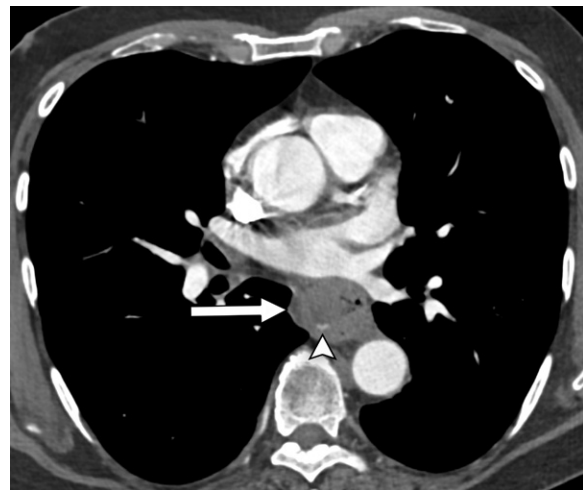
Esophagitis with possible active bleeding in a 62-year-old man with esophagitis, gastroesophageal reflux disease, and peptic ulcer disease who presented with chest pain and hematemesis. Axial arterial phase CT image shows diffuse esophageal wall thickening, fluid distending the esophagus, paraesophageal fluid (arrow), and a tiny focus of high attenuation in the posterior esophageal lumen that is concerning for active bleeding (arrowhead). However, contrast extravasation could not be confirmed on this single-phase CT image. At endoscopy (not shown), a bleeding deep mucosal tear was found in the esophagus, with an associated clot.
